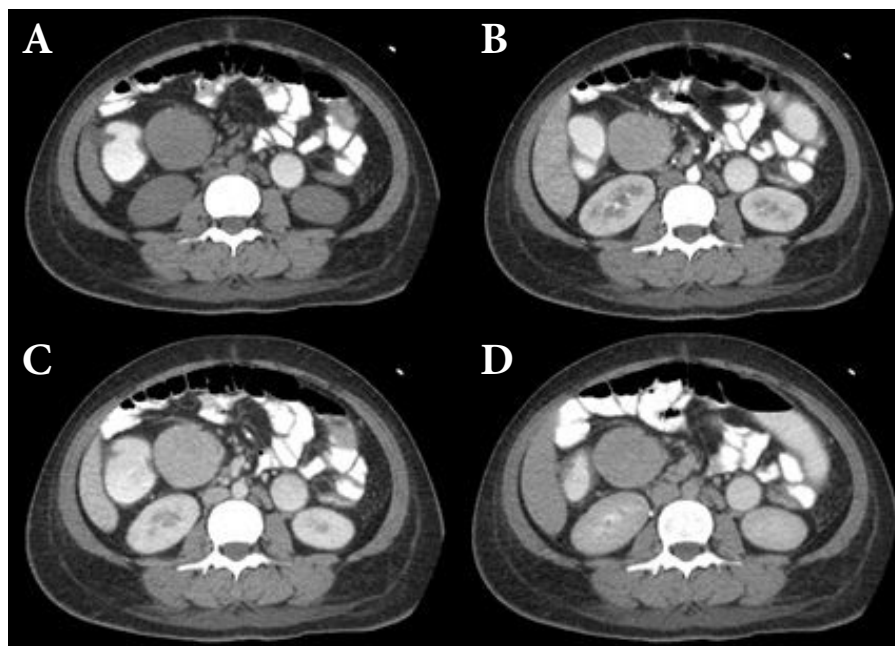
CT whole abdomen in plain (A), arterial (B), venous (C) and delayed (D) phases at 5 minutes shows a well-defined homogeneous mass with moderate enhancement at the right side of the mid abdomen. No intralesional calcification or necrosis is found.
